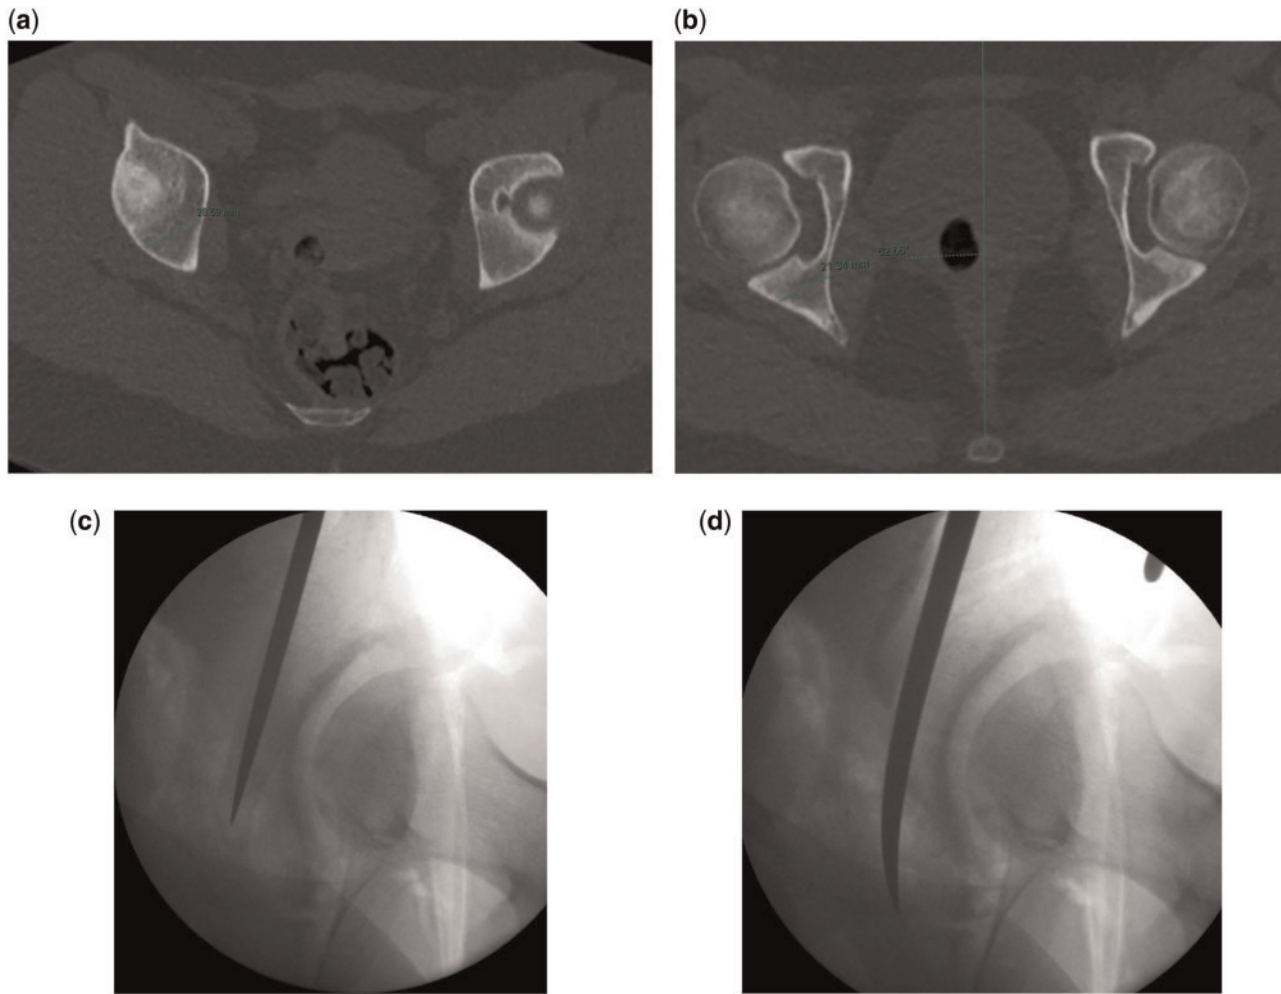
Examples of the posterior column width measurement performed at two levels of the acetabulum, (a) cranially, (b) CT slice at the level of the acetabular fossa, with measurement of posterior column angle for C-arm orientation, (c) fluoroscopic intraoperative image of retroacetabular iliac cut on the oblique view and (d) fluoroscopic intraoperative image of completion of the retroacetabular iliac cut.
